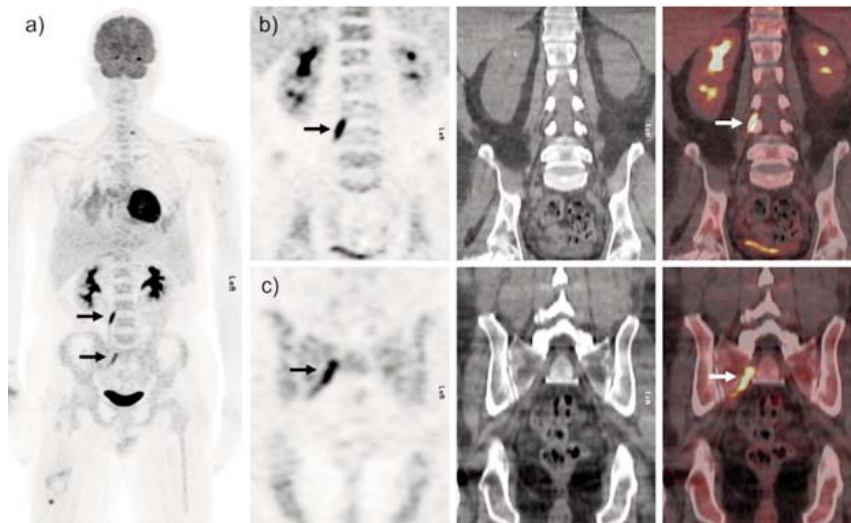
a) ^{18}F -FDG PET maximum intensity projection (MIP) image. (b,c) ^{18}F -FDG PET showed increased FDG uptake in the right L3 and S1 nerve roots (black arrow). Corresponding CT showed varying degrees soft-tissue-thickening with increase tracer uptake on fused PET/CT images (white arrow). Findings are consistent with multifocal neurolymphomatosis.
